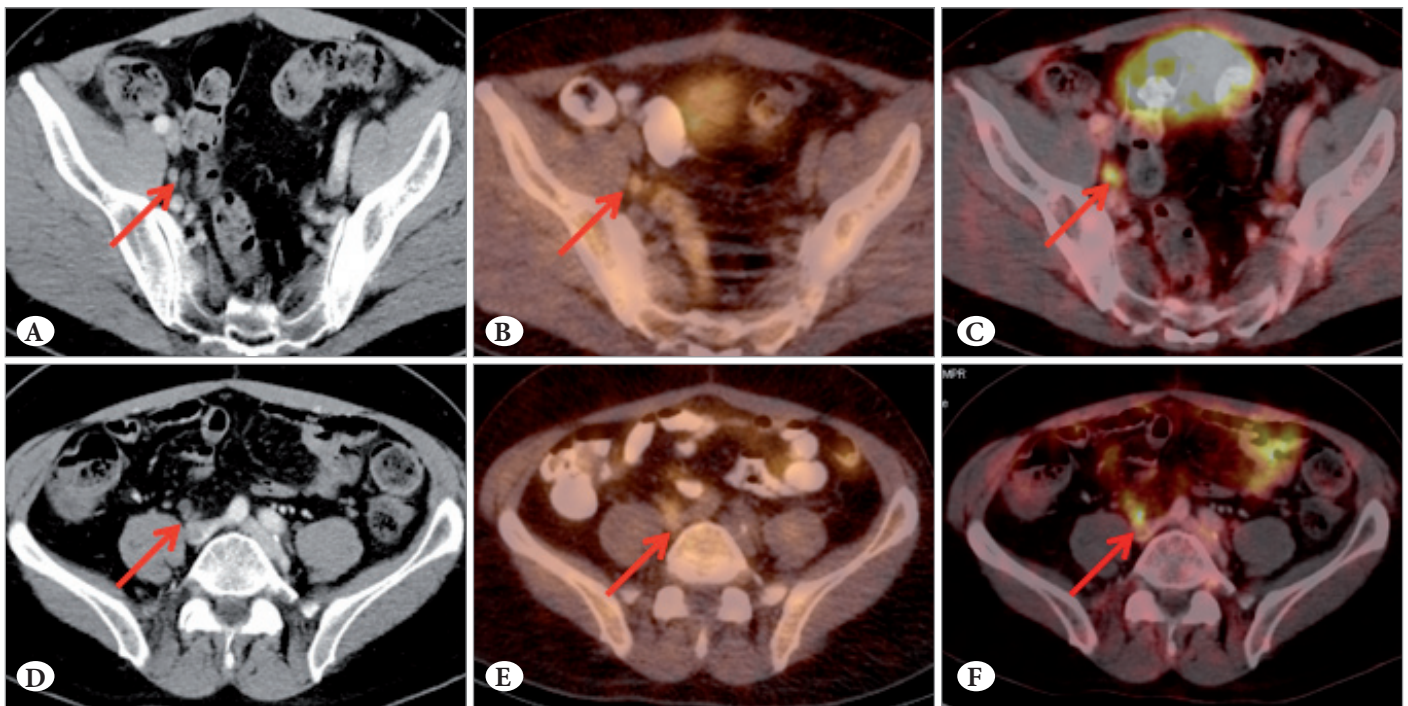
66 year old patient after radical prostatectomy and antihormonal treatment with a PSA of 0.77ng/ml. Contrast enhanced CT (A, D) demonstrates two non enlarged lymph nodes in the pelvis. While 11C-Choline PET/CT (B,D, fusion images) shows only a faint positivity of both lymph nodes hampering diagnostic confidence, high PSMA expression in ^{68}Ga -PSMA ligand PET/CT is highly indicative for lymph node metastases (C,F, fusion images).
